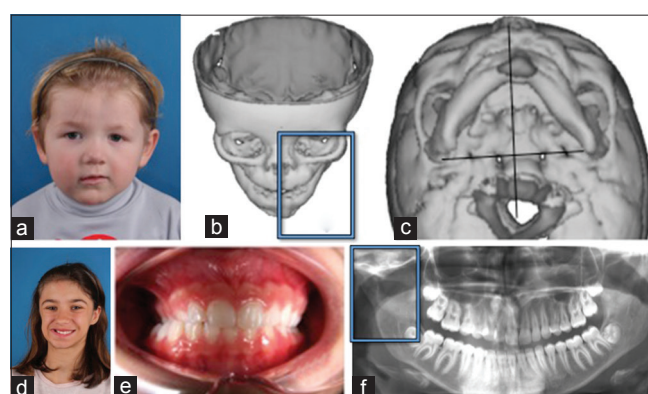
Pruzansky-Kaban Type I. All mandibular and temporomandibular joint components are present and normal in shape, but they are hypoplastic to a variable degree, compared to the contralateral side. (a) Frontal facial view of an affected girl during childhood; (b) three-dimensional (3D) reconstruction of a multi-slice computed tomography (CT) scan of the skull of a Type I deformity, with deviation of the mandibular midline to the left; (c) submento-vertical projection of the same 3D CT scan, demonstrating mandibular asymmetry; (d) frontal view of an affected girl during adolescence; (e) frontal view of the occlusion of the same girl in (d), demonstrating cross-bite on the right; (f) orthopantomogram of the girl in (d), showing the joint structures with a normal shape and location, but with a degree of hypoplasia. Note the downward growth of the skull base on the affected side
